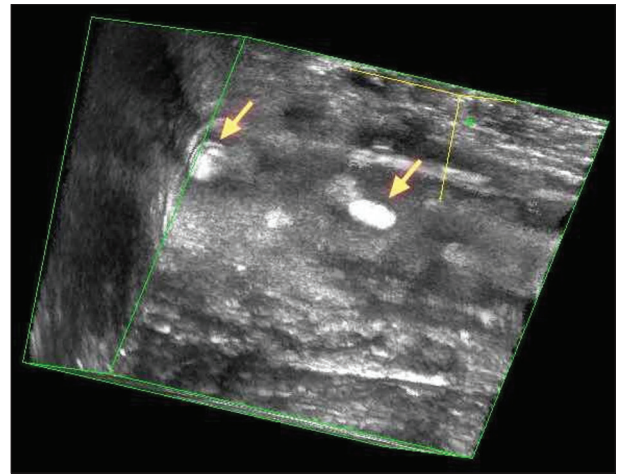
Three-dimensional endoanal ultrasound image of the identified seeds
